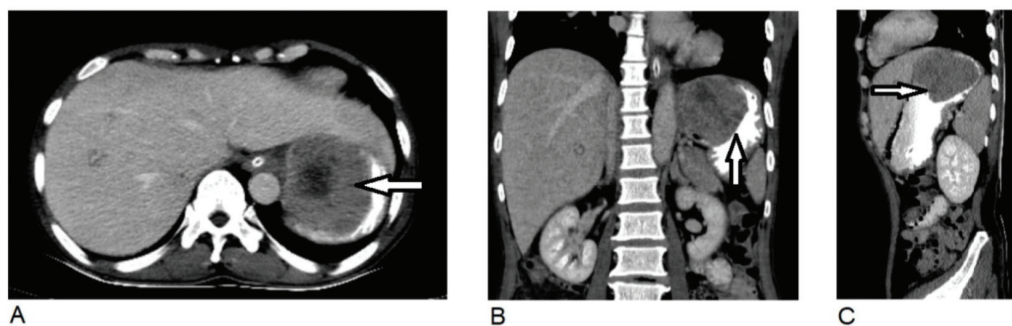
CT scan (a) Axial contrast-enhanced CT scan shows heterogeneous mass, which was measured about 7.9x7.0x6.9 cm in greatest dimensions and shows central necrotic portion, arising from the gastric fundus (arrow). (b) The coronal view shows the gastric mass causing luminal narrowing without gastric wall thickening (arrow). (c) The sagittal view shows the direct invasion of the gastric mass into the left lobe of the liver.
